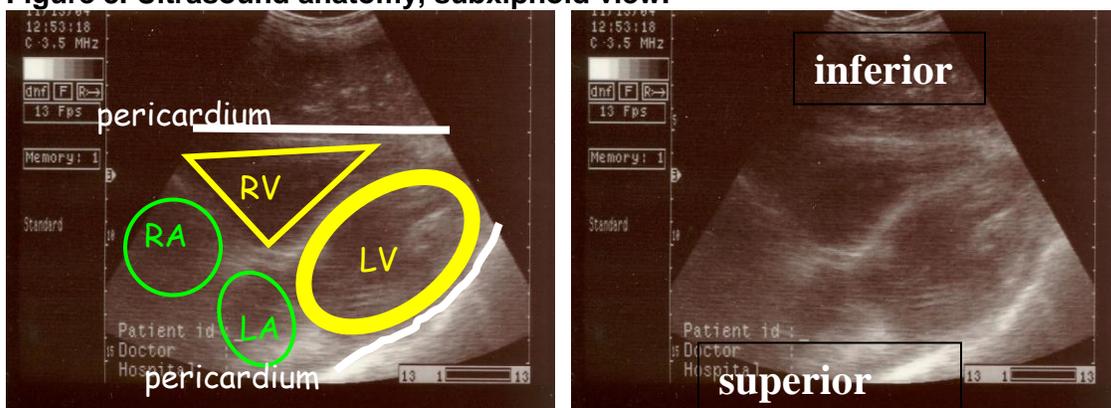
Ultrasound anatomy, subxiphoid view.
